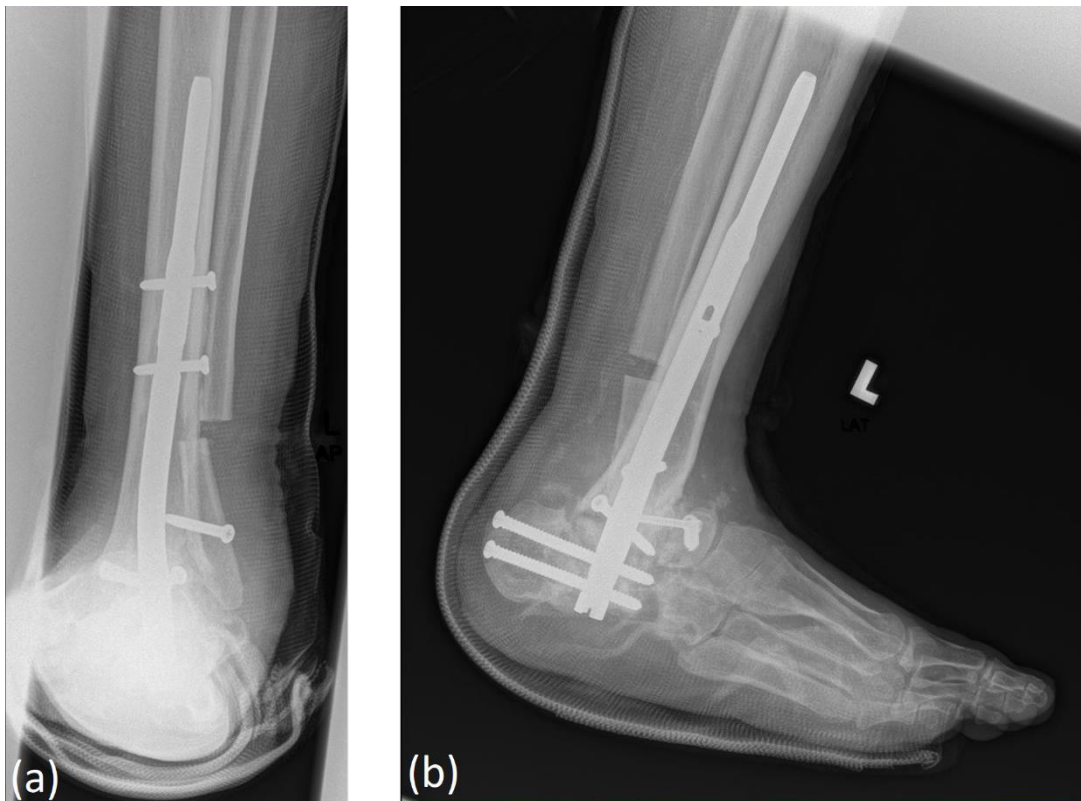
(a) AP view and (b) Lateral view of postoperative 4 months' radiographs of left ankle show good callus formation
